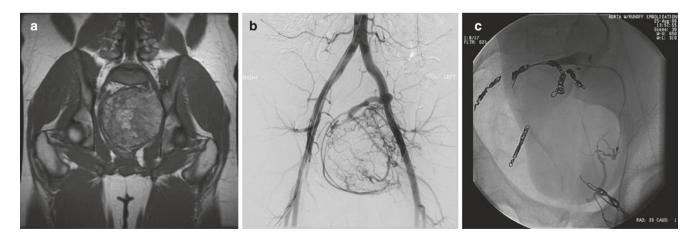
(a) MRI of hemangiopericytoma. (b) Angiogram of hemangiopericytoma. (c) Post-coil embolization of hemangiopericytoma. (Reused with permission of Mayo Foundation for Medical Education and Research, all rights reserved)
